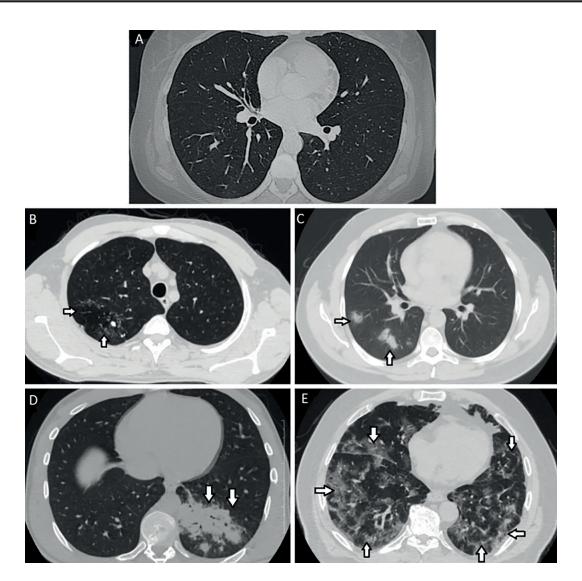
CT Images of COVID-suspected patients. A, CT image of a 28-year-old mildly symptomatic patient (CO-RADS 1). B, CT image of a 35-year-old patient with complaint of dry cough showing centrilobular nodular infiltration in the posterior segment of the upper lobe of the right lung and accompanying tree-in-bud sign (CO-RADS 2). C, CT image of a 45-year-old patient with hypertension showing focal consolidation in the right lung lower lobe superior segment with surrounding ground-glass opacities (CO-RADS 3). D, CT image of a 65-year-old patient with diabetes mellitus showing multifocal consolidation in the left lung lower lobe superior segment with surrounding ground-glass opacities (CO-RADS 4). E, CT image of a 72-year-old patient with a history of coronary artery disease showing bilateral multifocal patched ground-glass opacities (CO-RADS 5).
